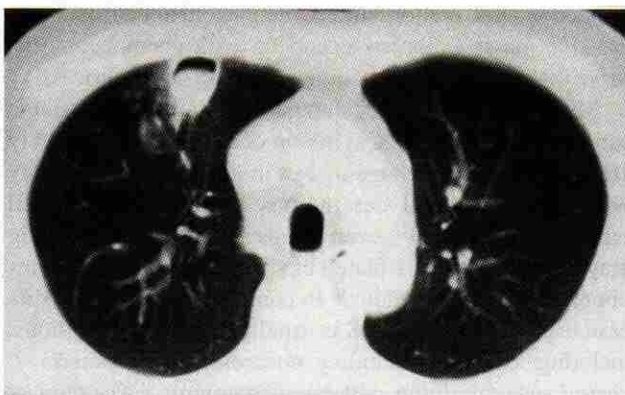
Computed tomogram of immunocompromised patient with invasive aspergillosis. Note cavitated mass (2 × 3 cm) with air crescent sign.
